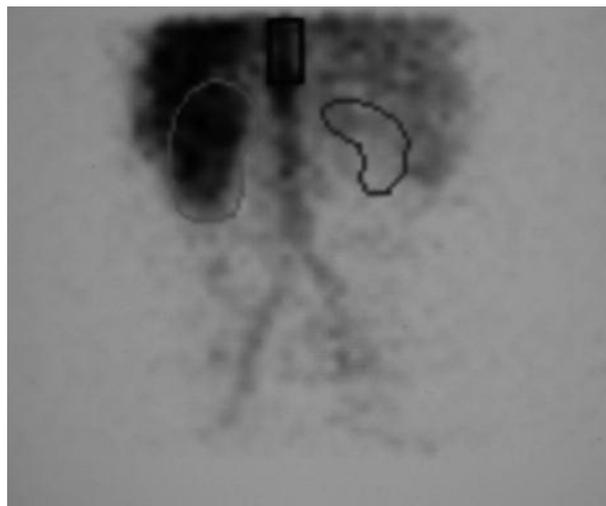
DMSA Renal scintigraphy; signs of atrophy in the right kidney.
